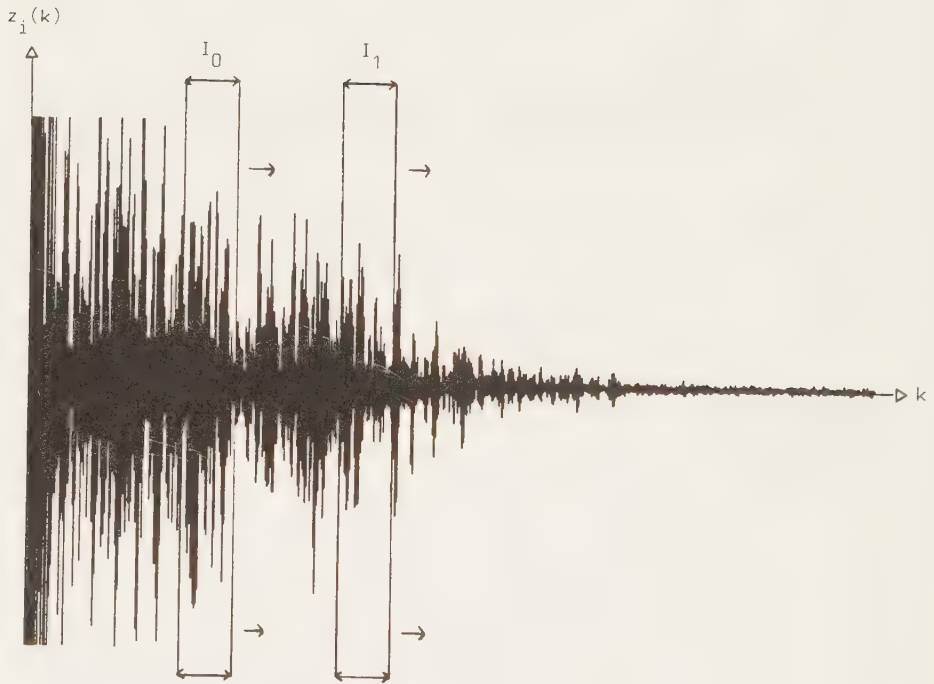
A received RF ultrasonic signal with sliding frequency domain estimation intervals.
